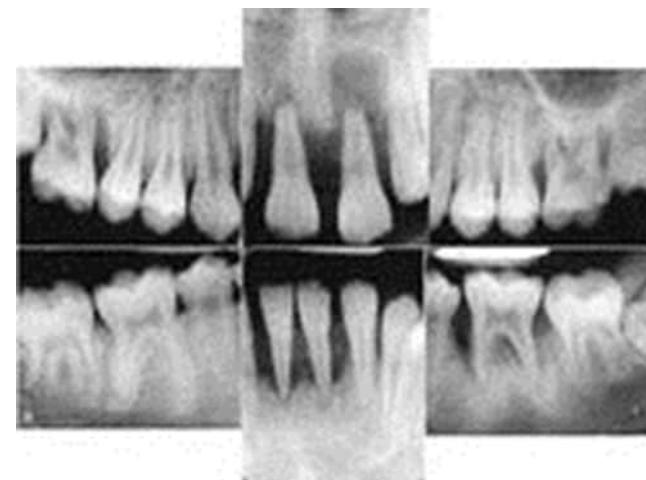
Radiographs of a 12-year-old boy with the Localized Periodontitis-Molar-Incisor Distribution. The films revealed loss of support in the incisor and first permanent molar areas. The maxillary central incisors, mandibular incisors, and first permanent molars were removed. Partial dentures were constructed.
